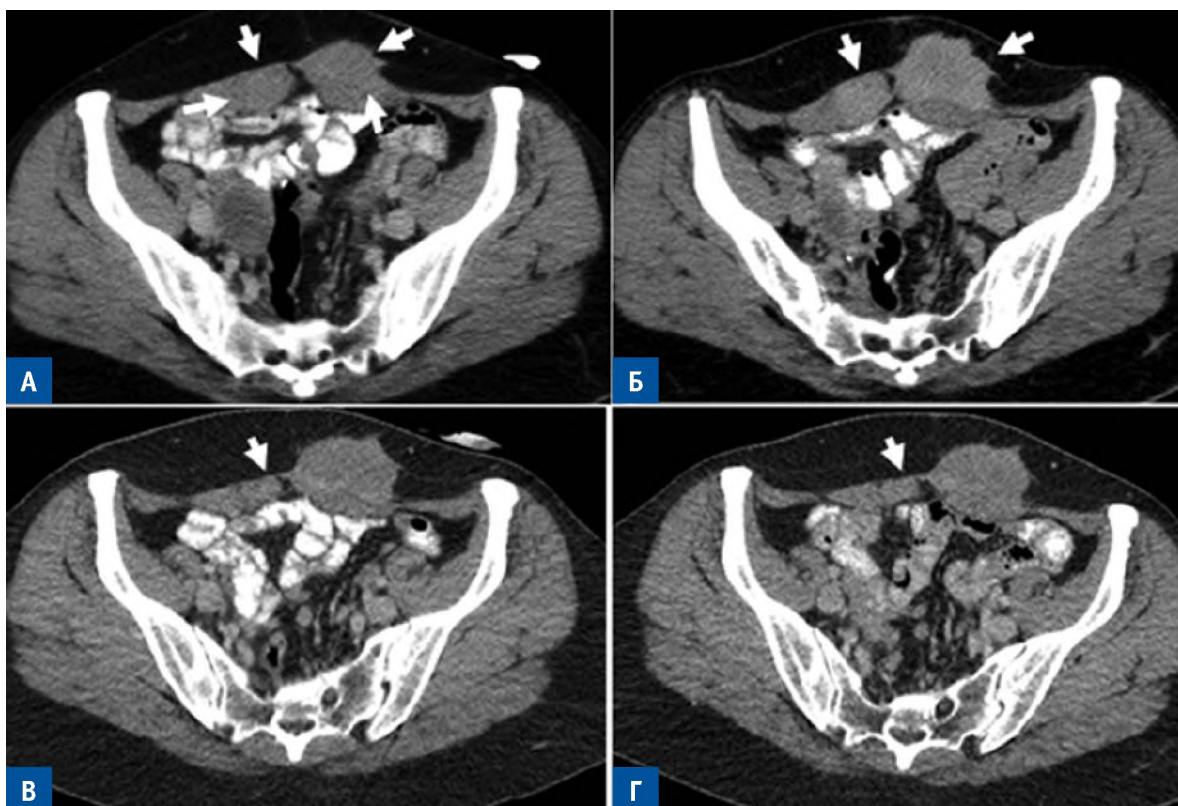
Desmoid-type fibromatosis of the anterior abdominal wall. CT with intravenous enhancement in patient Y., 36 years old. A — Tumors of the anterior abdominal wall in the area of the postoperative scar (arrows) with dimensions of 3.5×2.0 cm and 2.0×1.8 cm, ‘merging’ in density with muscle tissues. Б — after 6 months, there was an increase in the size of the masses up to 4.9×3.1 cm and 3.0×2.2 cm, respectively, and increased accumulation of the contrast agent compared to the muscles. В — 6 months after chemotherapy (methotrexate, vinorelbine), the tumor on the right (arrow) decreased by more than two times; the size of the second tumor did not change. Г — after 6 months of CT images did not change significantly
